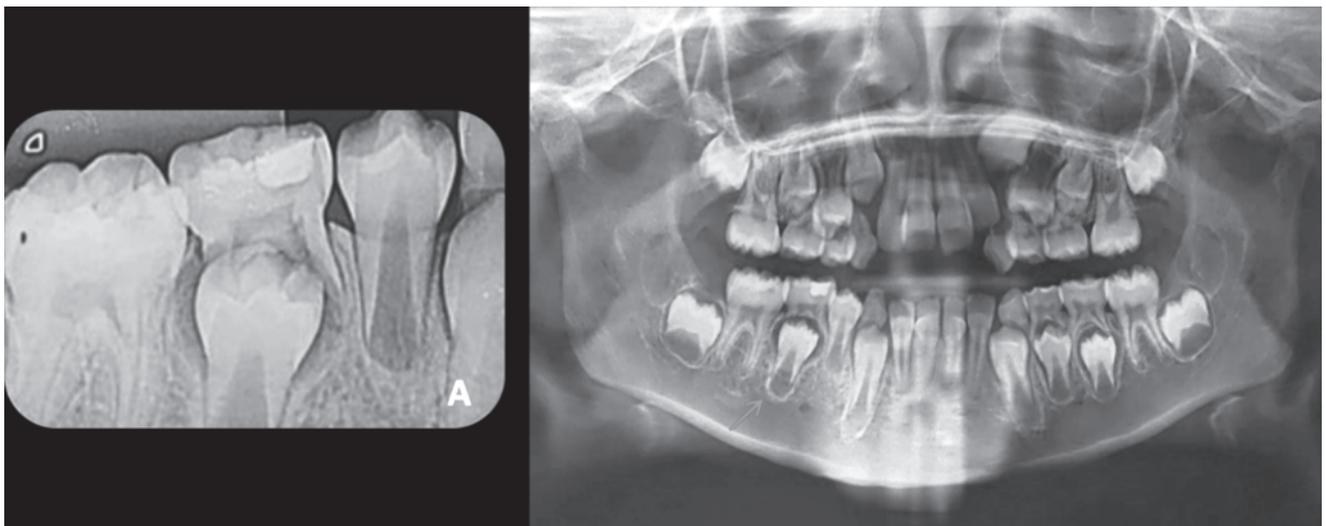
A - Periapical radiograph showing radiopaque restorative material in half of the dentin extension, with an underlying radiolucent area. B - Panoramic radiograph showing the root of the deciduous tooth had more than 2/3 rhizolyte and the permanent successor was in Nölla's stage 7.
